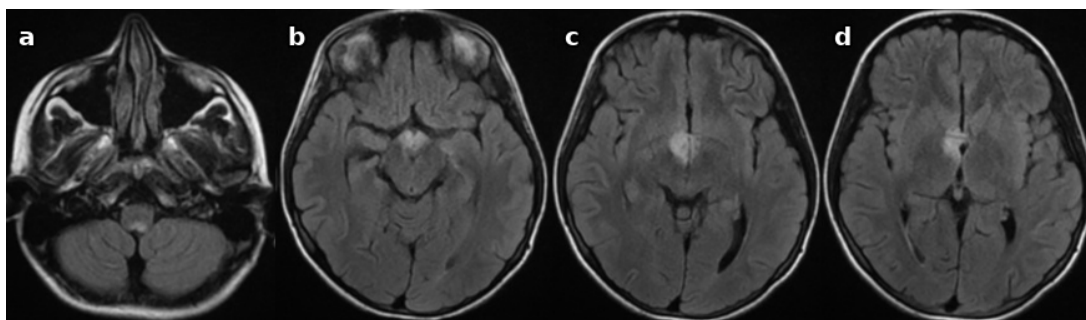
Axial T2-weighted FLAIR brain MRI images demonstrate hyperintense signal changes at the level of the (a) area postrema in the medulla oblongata, involving the (b) mammillary bodies and adjacent hypothalamic region, and in the (c,d) periventricular region surrounding the third ventricle.
